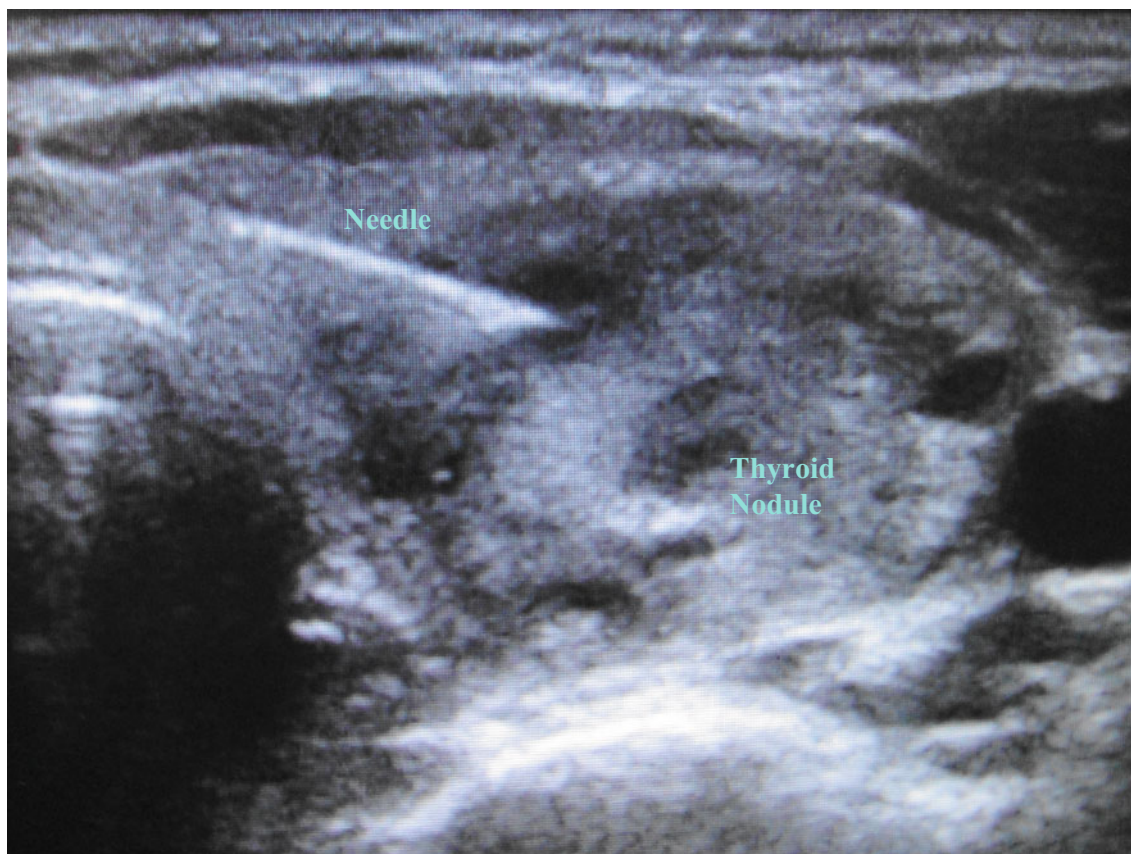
Ultrasound image of a mixed echogenicity thyroid nodule undergoing biopsy with a 25 gauge needle
